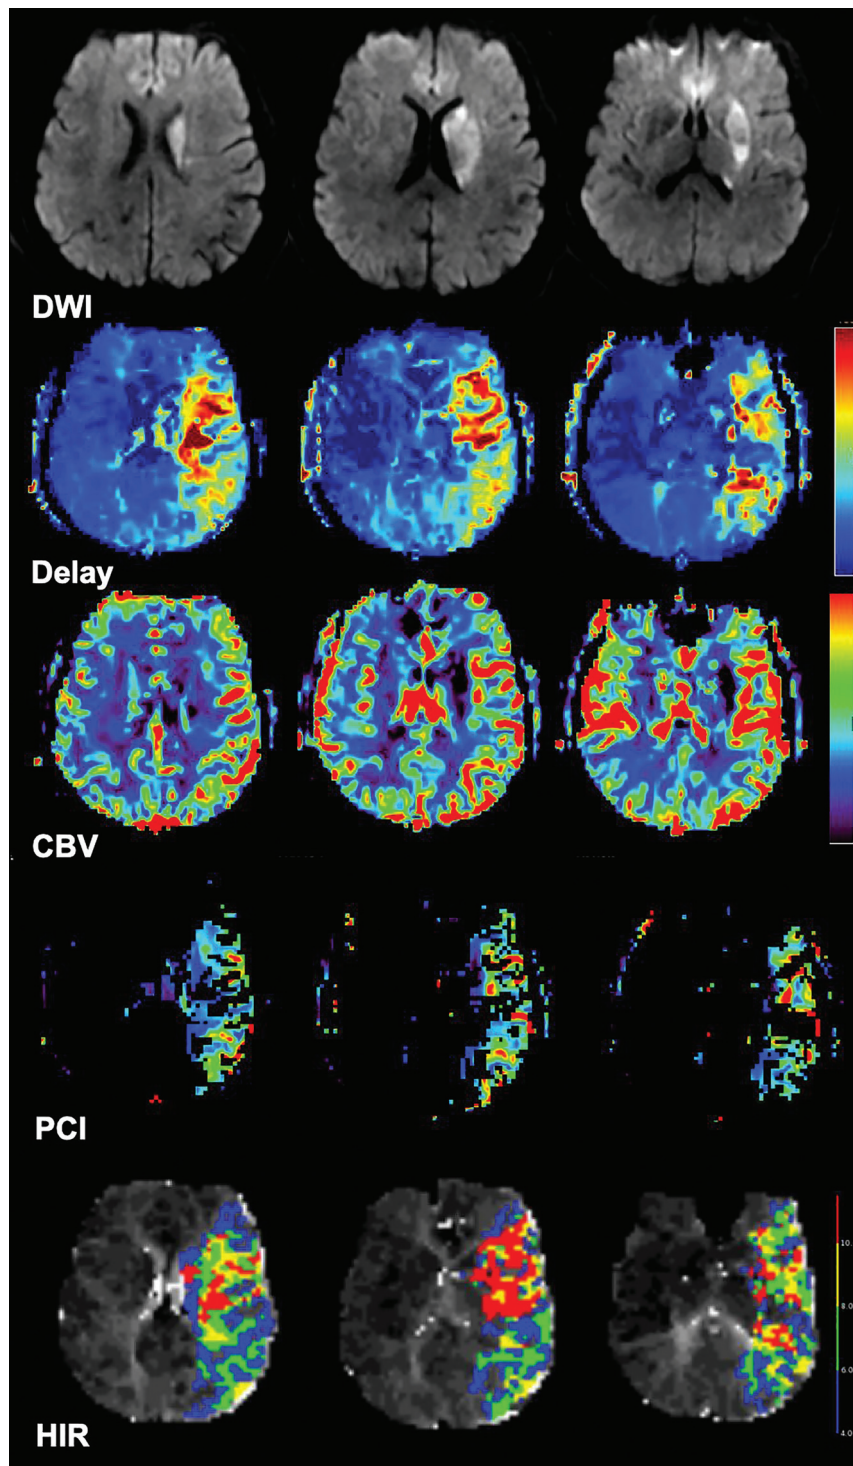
Example of concordance between the PCI and HIR. Adult patient with right hemiparesis who underwent MR imaging approximately 10 hours after symptom onset. The patient has a left M1 occlusion (not shown). Aligned axial DWI, delay, CBV, PCI, and HIR maps from MR perfusion are shown. There is an ischemic core involving the left basal ganglia. The PCI value is estimated at 132, suggestive of sufficient collaterals. The estimated HIR is 0.36, also suggesting sufficient collaterals. Baseline catheter angiography (not shown) revealed good collaterals (ASITN 3).
